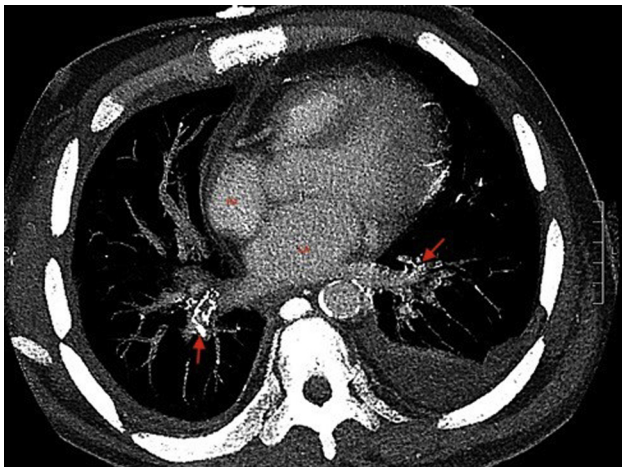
Computed tomography with contrast of pulmonary vein, left atrium, and right atrium in one view. Collateral vessels are seen in the pulmonary vein (*arrows*) that are draining into the left atrium. Collateral vessels seen by contrast enhancement in this image are better appreciated on the right pulmonary vein. Given proximity to the bronchus, this suggests bronchial venous complex involvement in collateral vessels and the final pathway into the left system. Normally, superficial bronchial veins drain to the azygos system, whereas deep bronchial veins drain into the pulmonary vein and sometime the left atrium. Anastomosis between these two venous systems in the setting of raised central venous pressure can explain the present findings.
